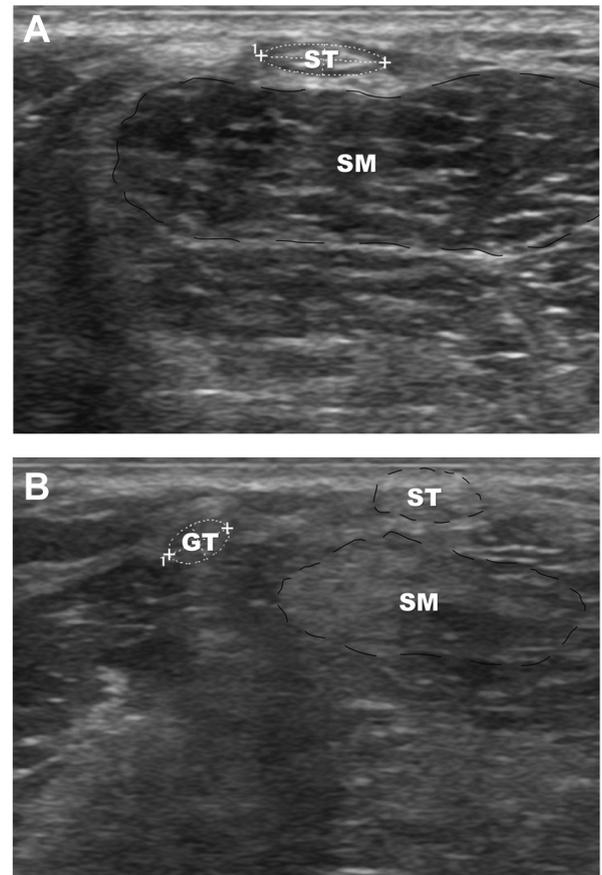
Ultrasound view of a medial aspect of a right knee just above the joint line. The cross-sectional area of every semitendinosus tendon (ST) (A) and gracilis tendon (B) was calculated with the ellipse tool (white dotted lines) of the ultrasound device. The semimembranosus muscle (SM) and ST are also seen delimited (black dotted lines).
